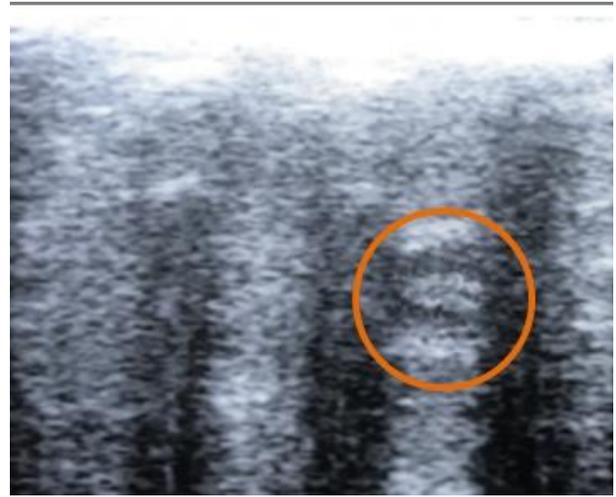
Ultrasonography of intermetatarsal space – right foot
